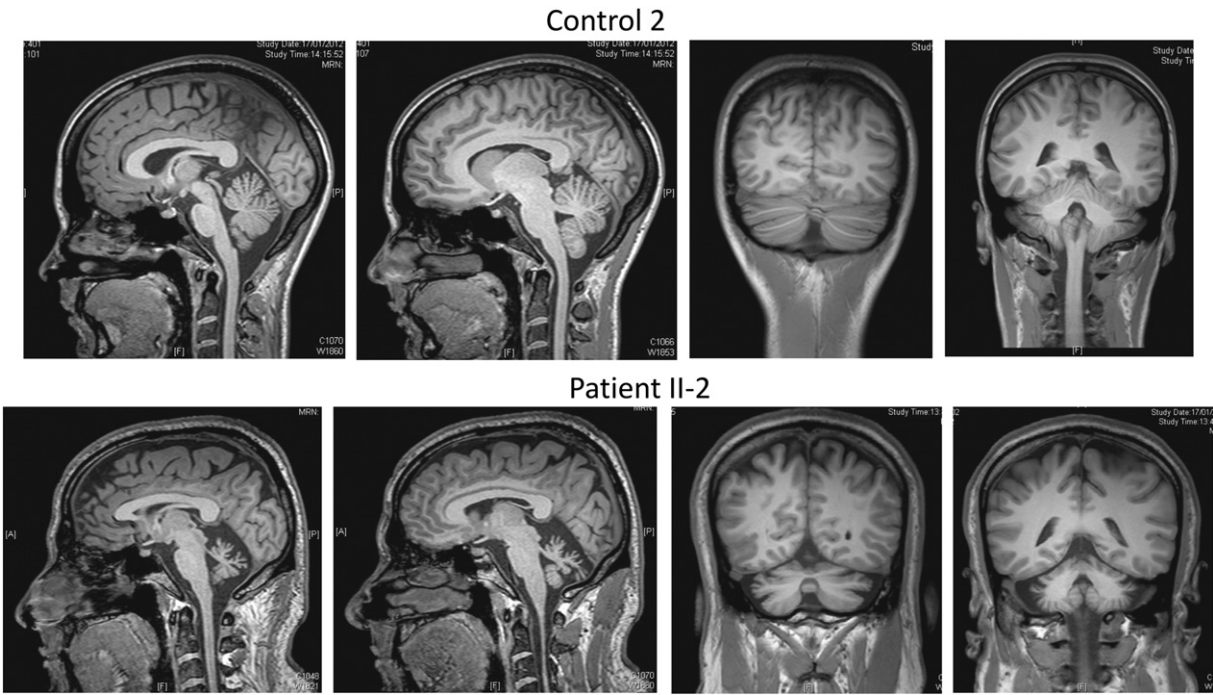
An example of non-contrast 3D turbo field echo T1-weighted sequence of brain MRI in one control and one patient, in sagittal (left) and coronal (right) views.
